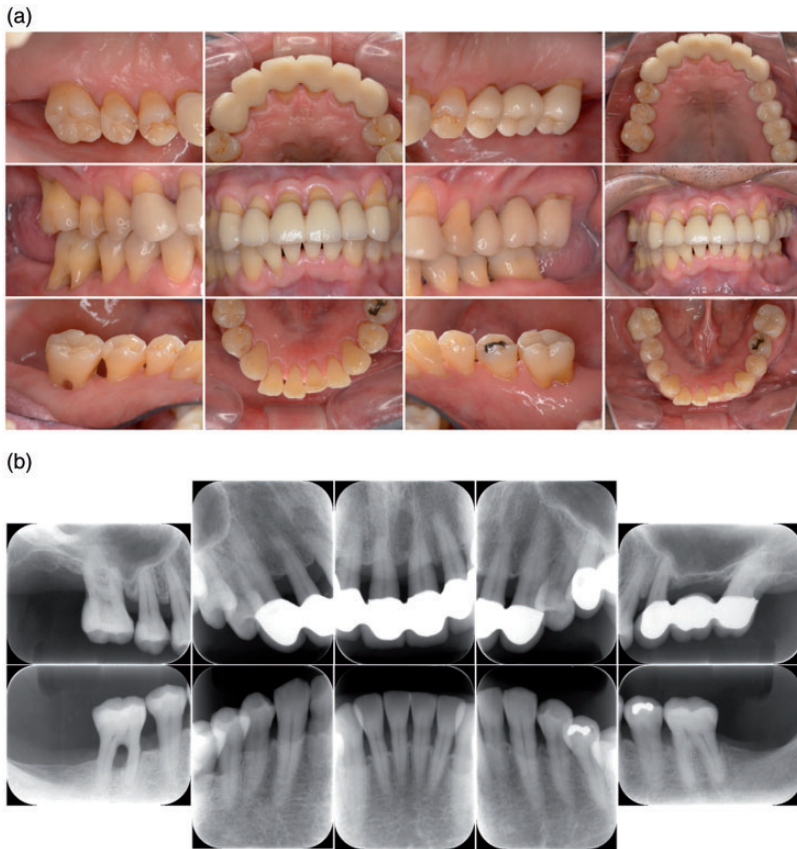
Oral view and radiographic images after supportive periodontal therapy. (a) Intraoral images after supportive periodontal therapy. (b) Radiographic images taken after supportive periodontal therapy.
